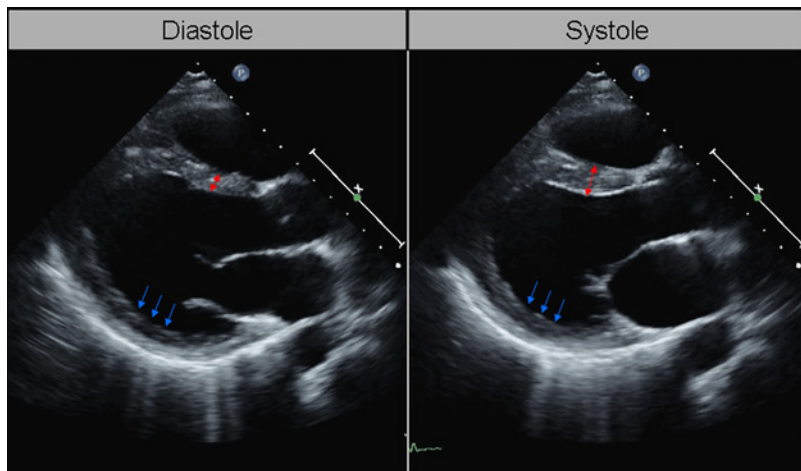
Two dimensional echocardiography images of a Becker muscular dystrophy (BMD) patient in the parasternal long axis in diastole (left) and systole (right). While normal systolic thickening is observed in the anteroseptal wall (red arrows), typical impaired systolic thickening is seen in the inferolateral segments (blue arrows).
